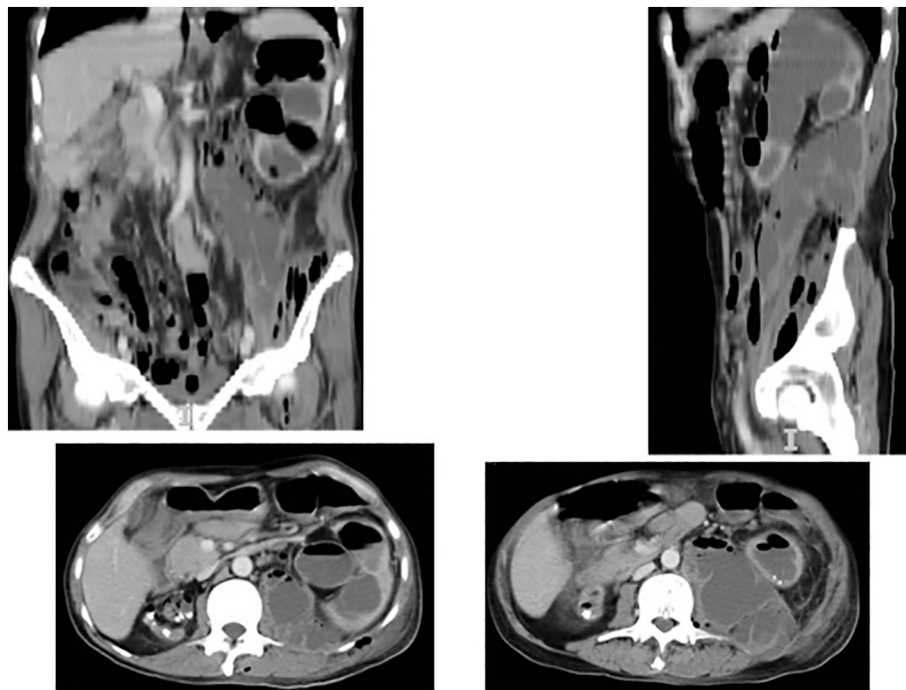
CT images. Bilateral emphysematous pyelonephritis. Left psoas abscess extending into the thigh.
